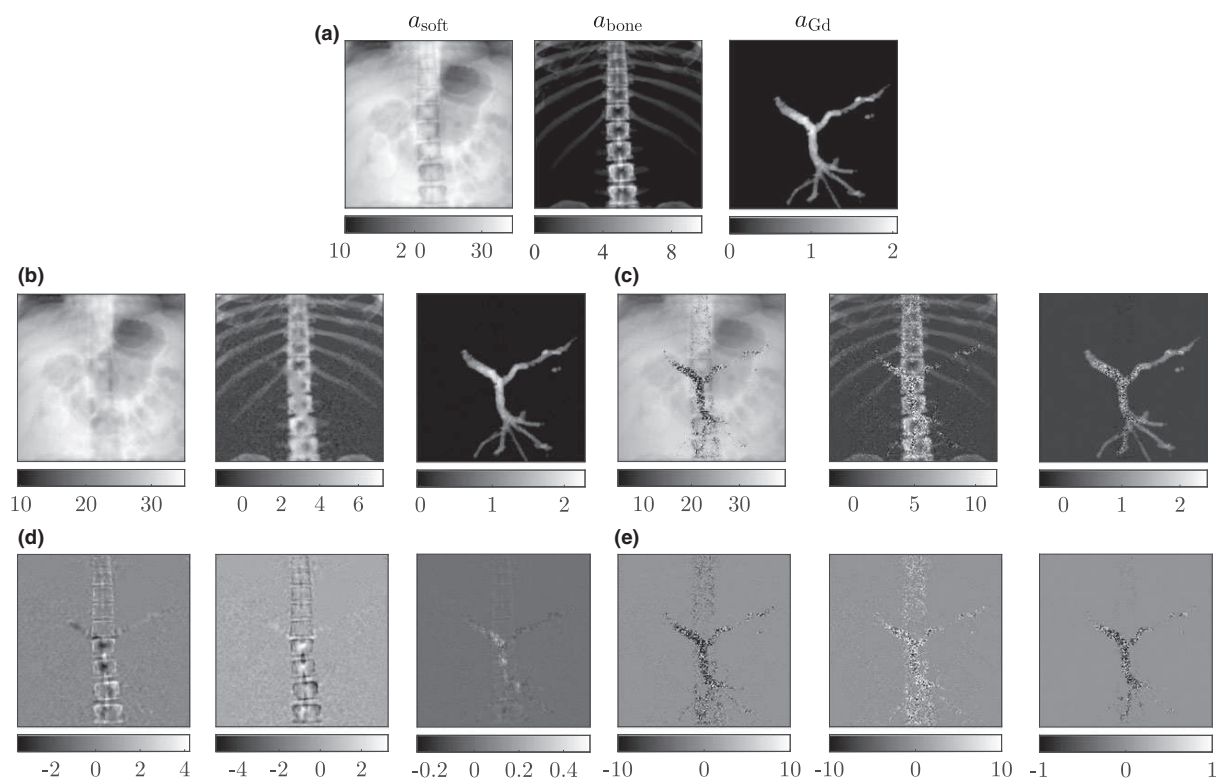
Basis material decomposition of (a) a reference radiography made of three materials (soft tissue, bone and gadolinium) with (b) spatial regularization [J29] and (c) no regularization [48]. Figures (d) and (e) are the differences of (a) with (b) and (c), respectively. Figure re-printed from [J29].
